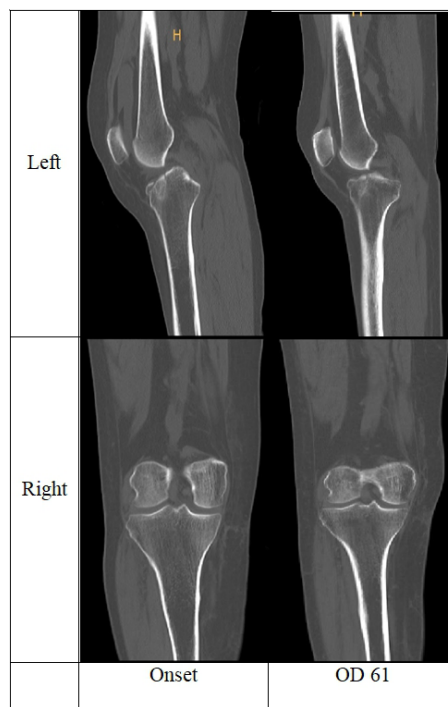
Computed tomography of bilateral tibia. OD, onset day: days after the onset.
